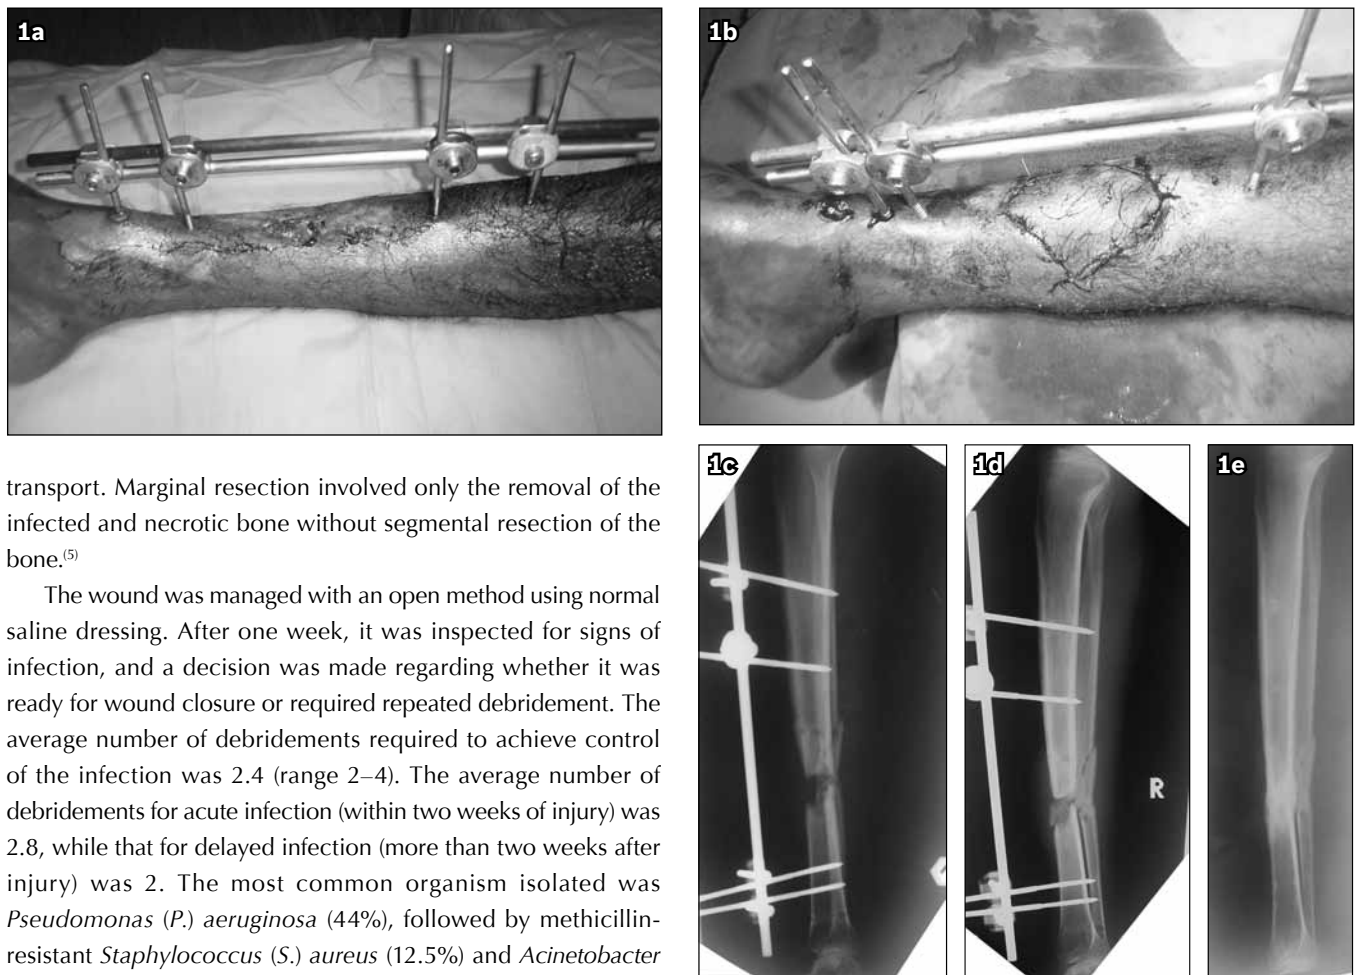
Photographs of the leg show (a) sinus surrounded by scar tissue in the midshaft of the tibia; and (b) sural flap that covers the wound defect following resection of the scar tissue and infected bone. Lateral plain radiographs show (c) the diaphyseal defect following marginal resection; (d) the tricortical iliac bone graft to bridge the bone defect; and (e) consolidation of the fracture eight months post bone grafting.
